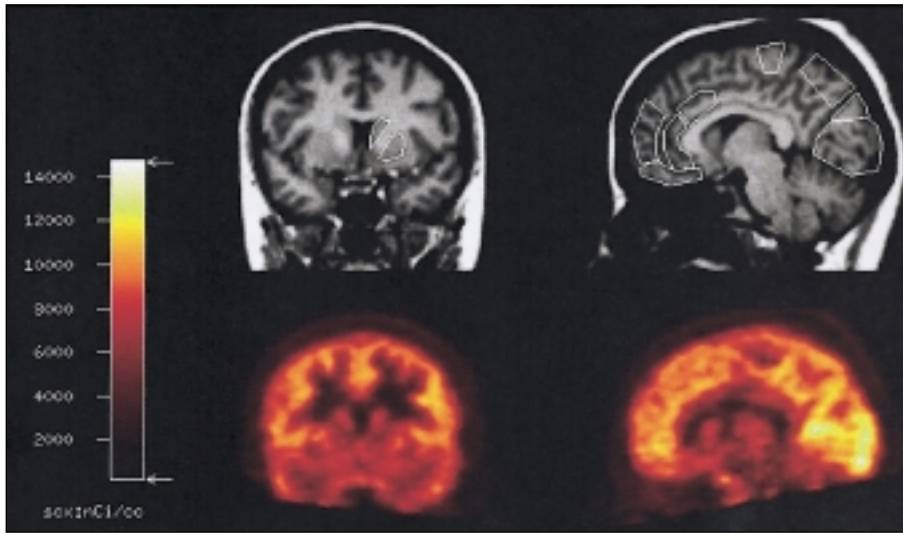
Coronal and paramedian sagittal slice of a T₁-weighted MRI image with delineated ROI-templates (upper row) and the corresponding ¹⁸F-altanserin PET images (bottom row)
